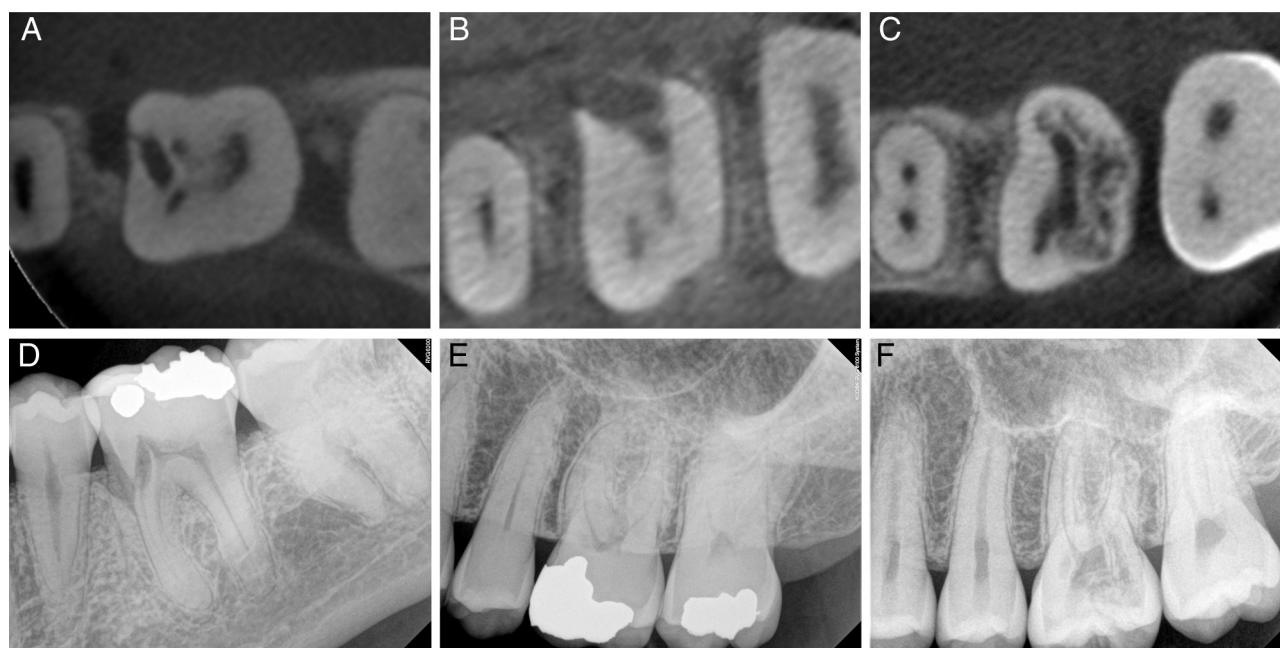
Rohde classification system. (Top) Example CBCT axial slices depicting (A) Rohde class 1, (B) Rohde class 2, and (C) Rohde class 3. (Bottom) Corresponding periapical images of the teeth depicted in the CBCT slices above them: (D) PA image of Rohde class 1, (E) PA image of Rohde class 2, and (F) PA of Rohde class 3.
